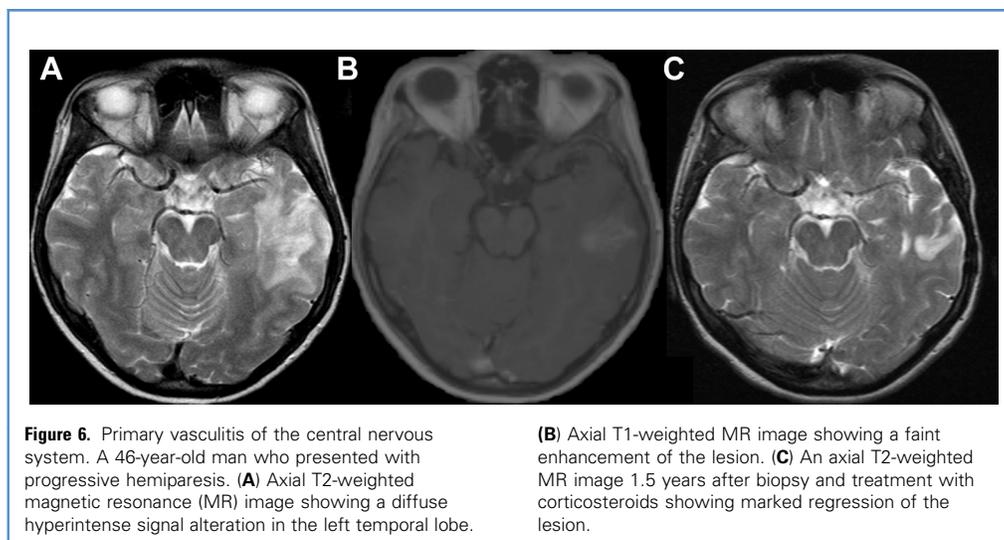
Primary vasculitis of the central nervous system. A 46-year-old man who presented with progressive hemiparesis. (A) Axial T2-weighted magnetic resonance (MR) image showing a diffuse hyperintense signal alteration in the left temporal lobe.
